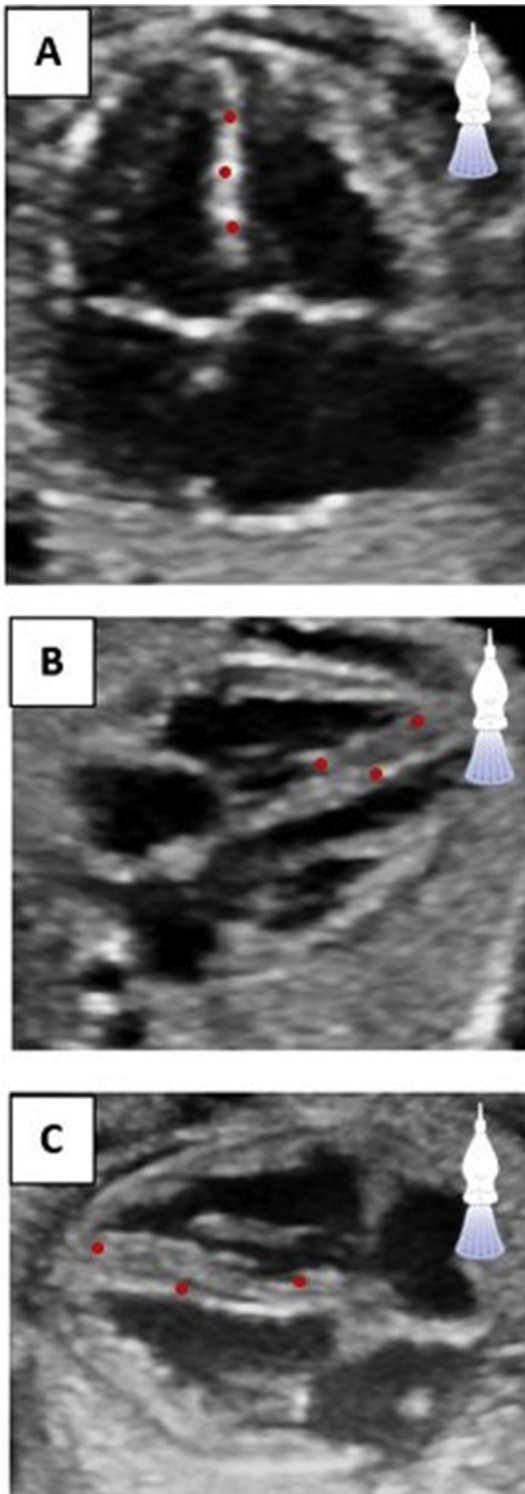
(A) Within the up/down angle of insonation, the myocardium is thinly depicted and the kernels are all in the same axial alignment compared with the ultrasound beams. It requires an extremely high resolution to be able to distinguish between the individual kernels (see also Figure 1). (B, C) The thickness of the myocardium is fully displayed in the perpendicular and oblique angles of insonation, allowing more kernels to be observed that are also aligned differently. Therefore, with a lower resolution it will still be possible to adequately distinguish between the individual kernels.
